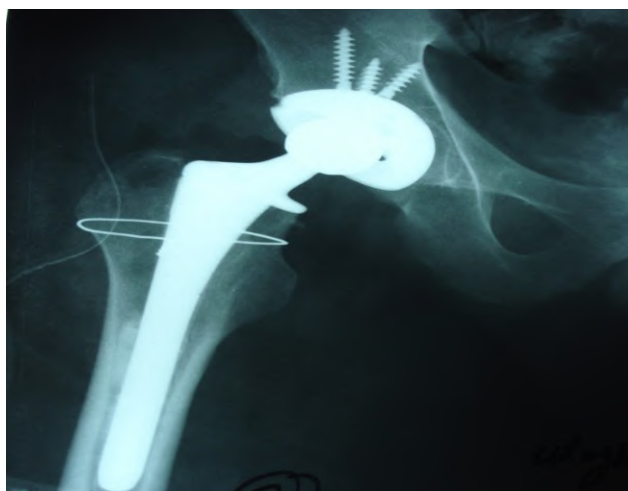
Post operative X-ray of patient in fig. 2
